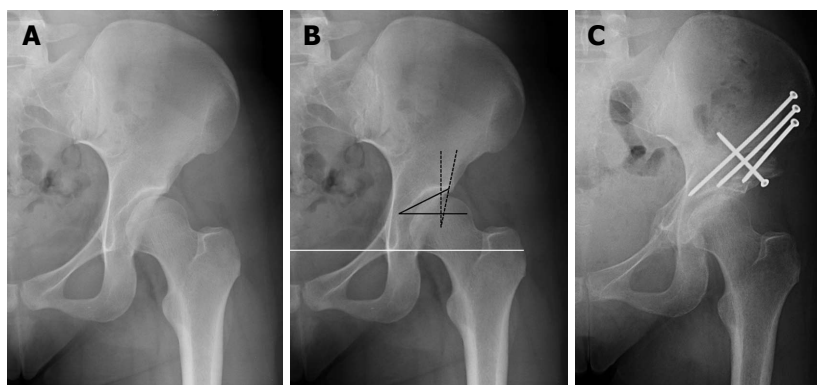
Acetabular radiographic measurements and correction. Pre-operative (A) antero-posterior radiograph of a hip with classic dysplasia. Basic radiographic measurements of dysplasia (B) include the lateral center edge angle (dashed black line; measure of lateral acetabular coverage), Tönnis angle (solid black line; measure of sourcil angle); the solid white line is the inter-teardrop line, which is the reference for pelvic tilt in the coronal plane; an anterior center edge angle on a false profile view completes the basic radiographic work-up. The post-operative (C) antero-posterior radiographic view of the same hip demonstrating satisfactory acetabular reorientation to correct bony dysplasia.
